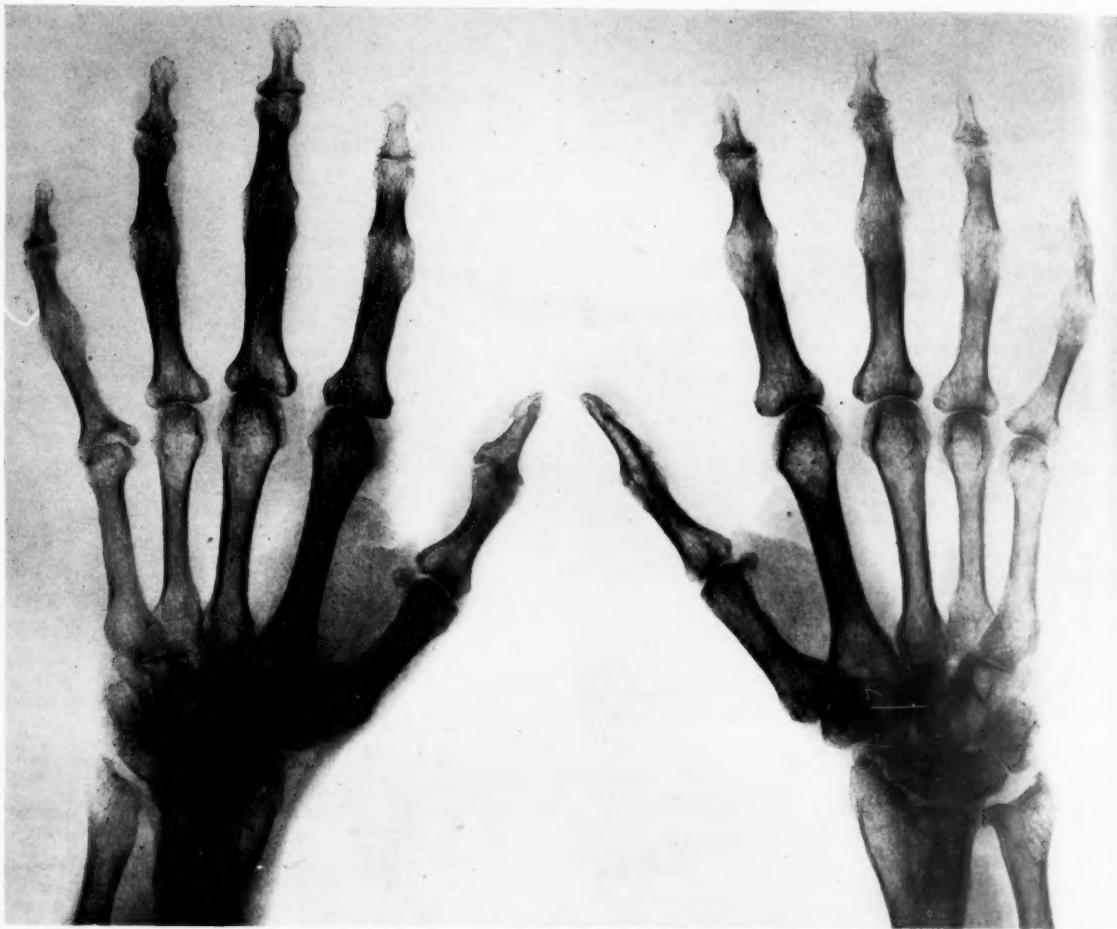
Case 4, radiograph 12 years after onset showing complete bony ankylosis of the proximal interphalangeal joints of both hands and of the distal joints of the right little finger and thumb. The metacarpophalangeal joint of the left little finger shows a cup-shaped deformity of the phalanx. Wrists show decrease in size of the proximal carpal bones.
